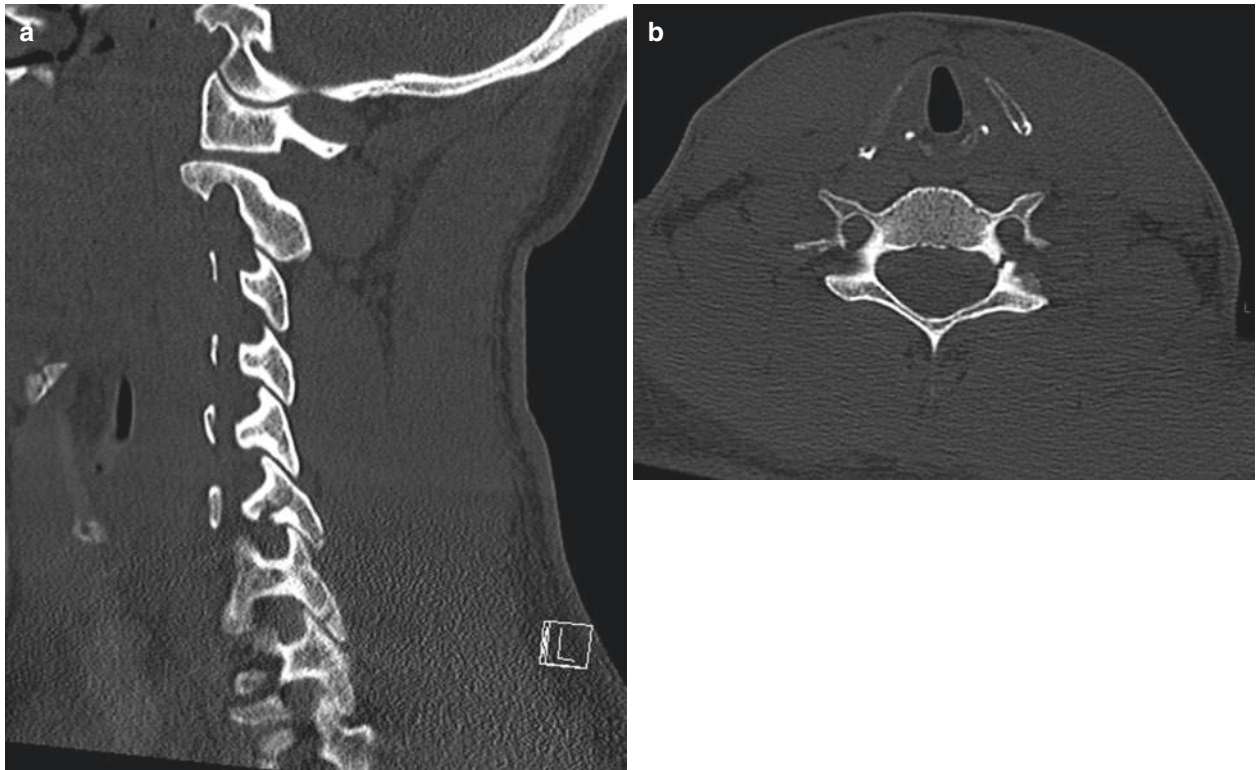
25 year old male surfer who sustained a neck injury. (a) Sagittal CT reconstruction reveals left lateral mass fractures at C6 and C7. (b) Axial image demonstrates an additional left pedicle fracture extending
